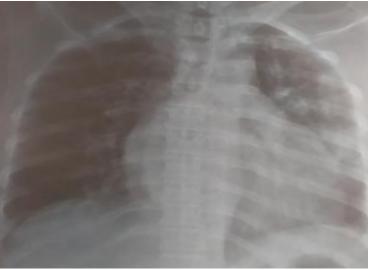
Chest x-ray found cardiomegaly with a rectilinear left middle arch
